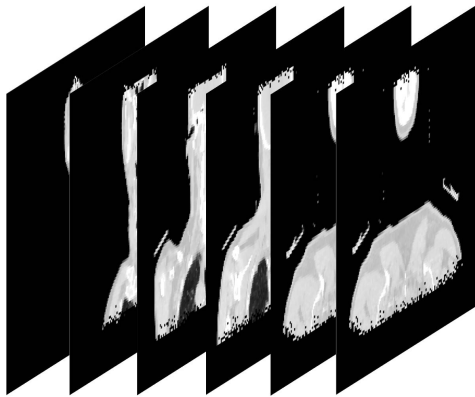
3D CT scan obtained by assembling 2D images for each slice of the patient.
